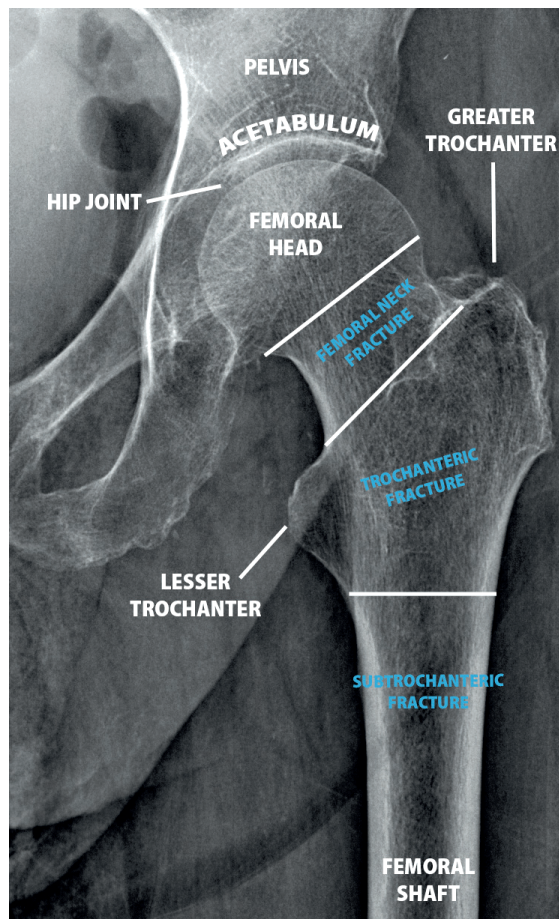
Radiograph of the hip joint and the proximal femur.
